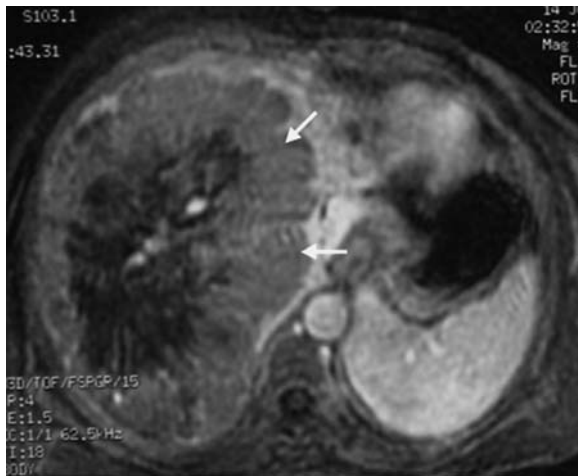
Axial, gadolinium enhanced MRI of the liver of a patient with HCC shows a large, peripherally enhanced lesion (arrows) replacing the right lobe. The patient was unresectable owing to the size of the tumor. Decision was made to treat the patient with TACE for palliative reasons
